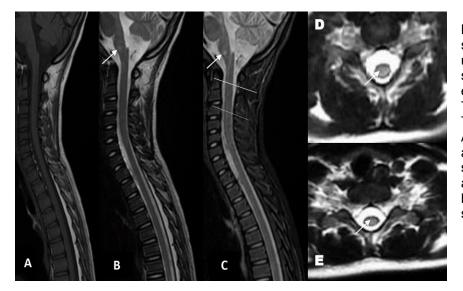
Cervico-thoracic spinal cord MRI performed upon admission: Sagittal sections T1-weighted spin echo sequence (A), T2-weighted sequence (B), T2-STIR sequence(C). Additionally, T2-weighted axial sections spin echo sequence (D and E), show a transverse myelitis with a bulbo-medullary junction significant lesion.
